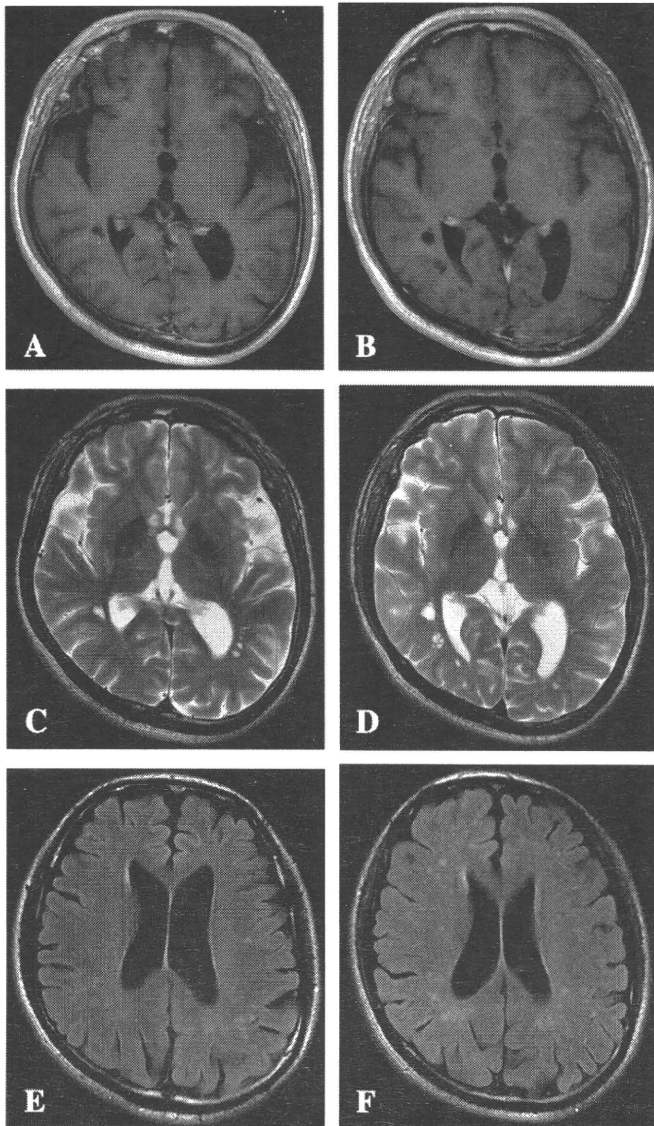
Brain MRI of Patients 1 (A, C, E) and 2 (B, D, F) showed enlarged perivascular space around the posterior horn of the lateral ventricle (A–D), and small hyperintense lesions in deep white matter (E, F). There is no thickening and abnormal enhancement of the intracranial dura mater (A, B: T1-weighted image with gadolinium enhancement; C, D: T2-weighted image; E, F: fluid attenuated inversion recovery image).
